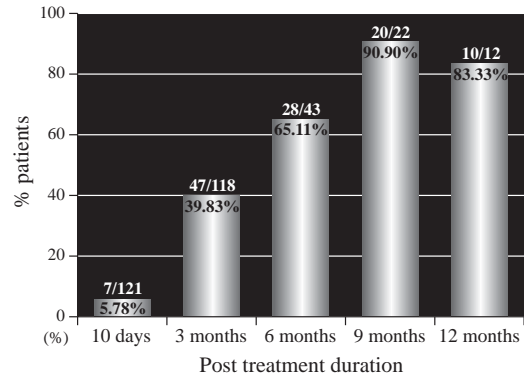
Percentage of patients whose liver feature returned to normal shown by ultrasound examination.
